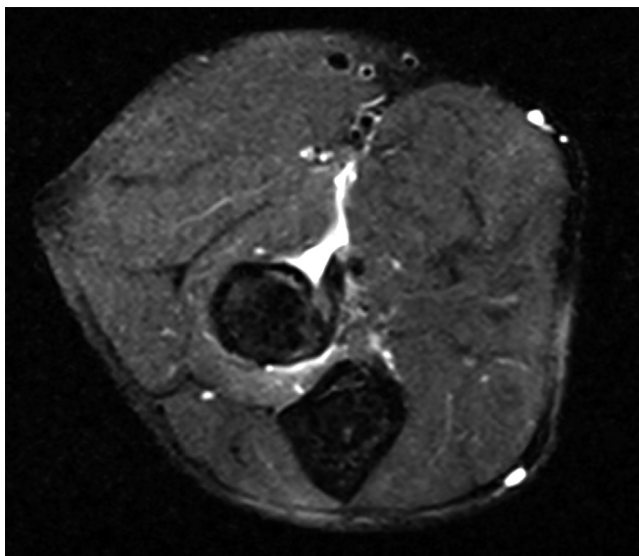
Standard magnetic resonance imaging view of distal biceps tendinosis. It should be noted that only a small portion of the tendon can be seen per the image. Courtesy of MoRe Foundation.
